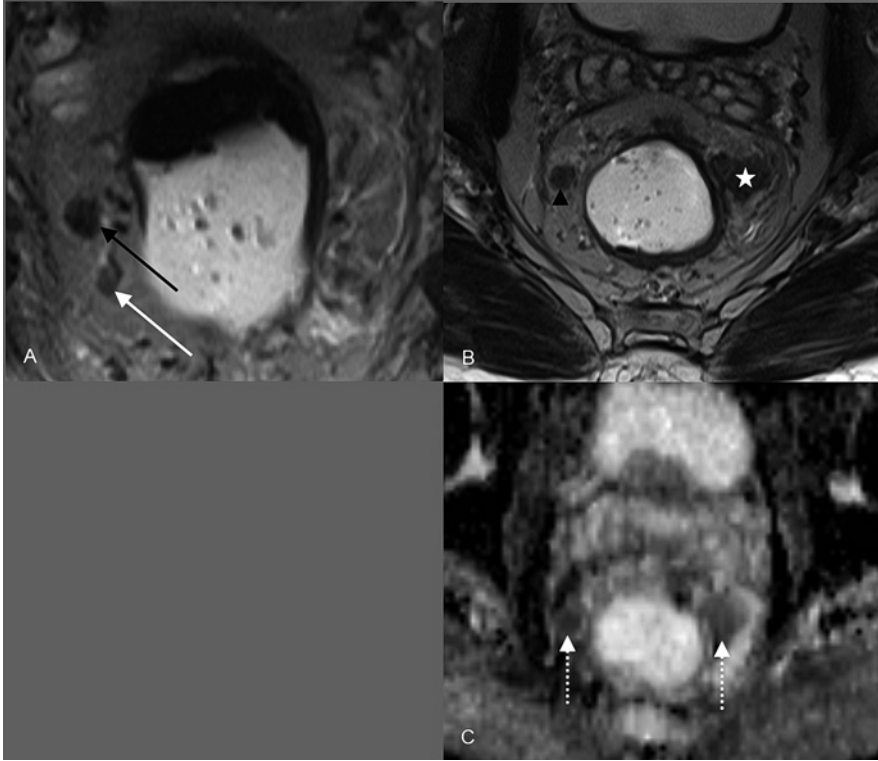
Axial T2-weighted MR image through the rectum (a) showing a small smoothly margined, oval mesorectal lymph node (*white arrow*) which is likely benign, inferior to an enlarged, irregularly margined rounded lymph node (*black arrow*) which is likely malignant. A more caudal axial image (b) shows a similar-appearing malignant lymph node (*black arrow head*) and an opposite tumor nodule (*white star*). The corresponding slice from the apparent diffusion coefficient map (c) derived from the diffusion-weighted images (not shown) shows low signal within both lesions (*dashed white arrows*) indicating restricted water diffusion, compatible with tumor
